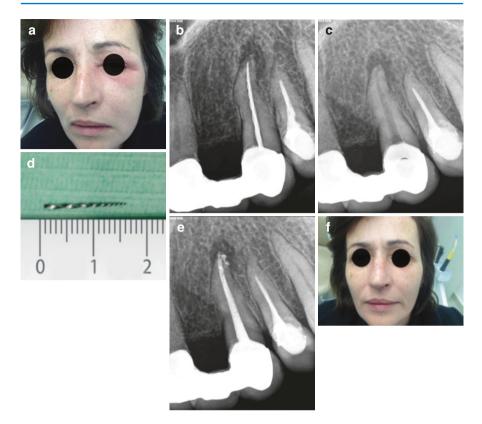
(a) Clinical appearance of a healthy 45-year-old woman presented with swelling and fever lasting 3 days, despite self-administered antibiotics (amoxicillin 625 mg \times 3 for 3 days). According to her dental history, she had a continuous discomfort since the RCT and bridge work performed 18 months earlier. (b) Preoperative radiograph revealed the presence of an endodontic instrument fragment with both ends within the root canal "covering" approximately the whole length of the canal. (c, d) Retrieval of the fragment, instrumentation, and dressing of the root canal with Ca(OH)₂ for 14 days. (e) Immediate post-obturation radiograph. (f) Clinical picture of the day of completion of RCT (Courtesy of Dr. K. Mastoras)
